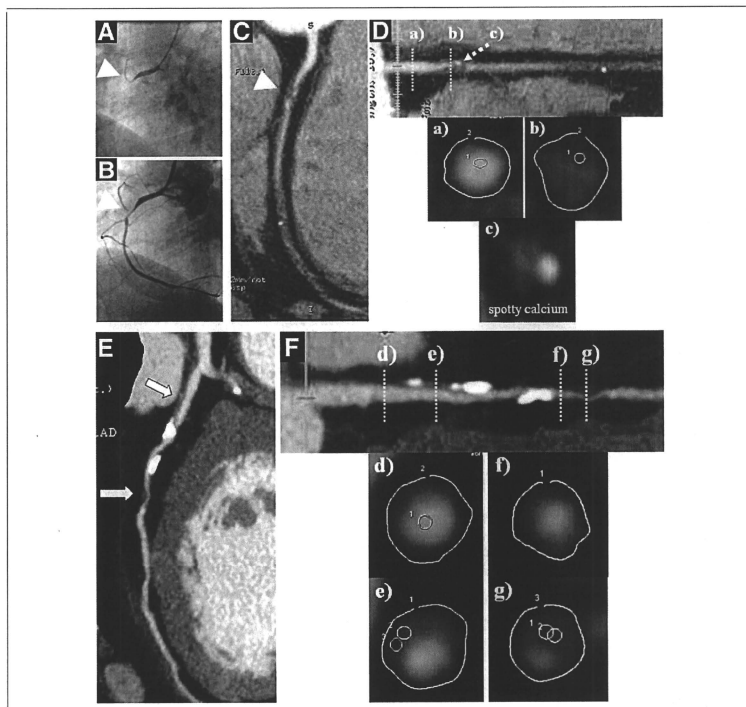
Invasive Angiography and Coronary CT Angiography in a 58-Year-Old Man With NSTEMI
